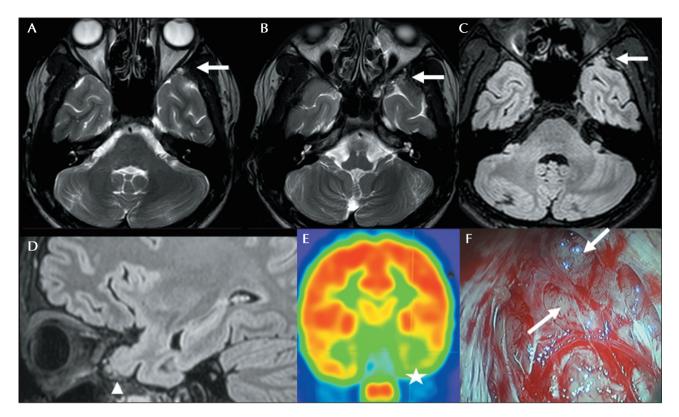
(A, B) Axial T2 image. (C) Axial FLAIR image showing an encephalocele (arrow) protruding through the left middle cranial fossa. (D) FLAIR sagittal image of encephalocele protruding through the left middle cranial fossa (arrowhead). (E) PET image showing left temporal hypometabolism (star). (F) Intraoperative photograph of encephalocele showing deficient dura and gliotic brain, terminating into bony pits (arrow) (Case 1).
